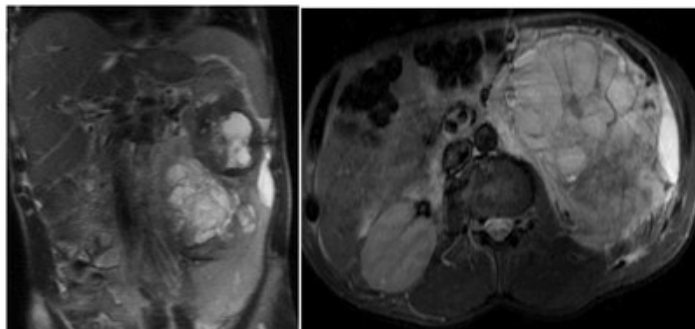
MRI images of the renal mass
